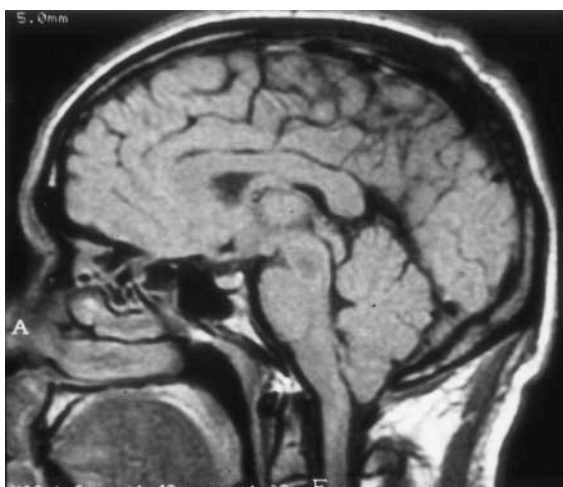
Case 2: MRI in sagittal section. Cerebellar herniation is observed.
